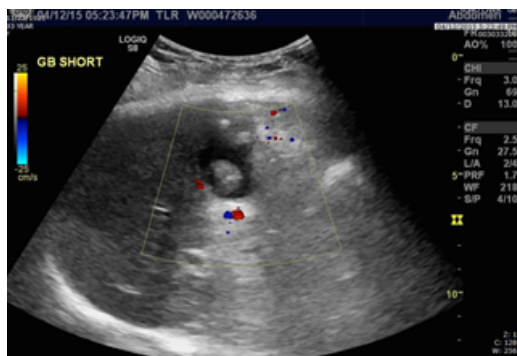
Sonographic images of gall bladder.
